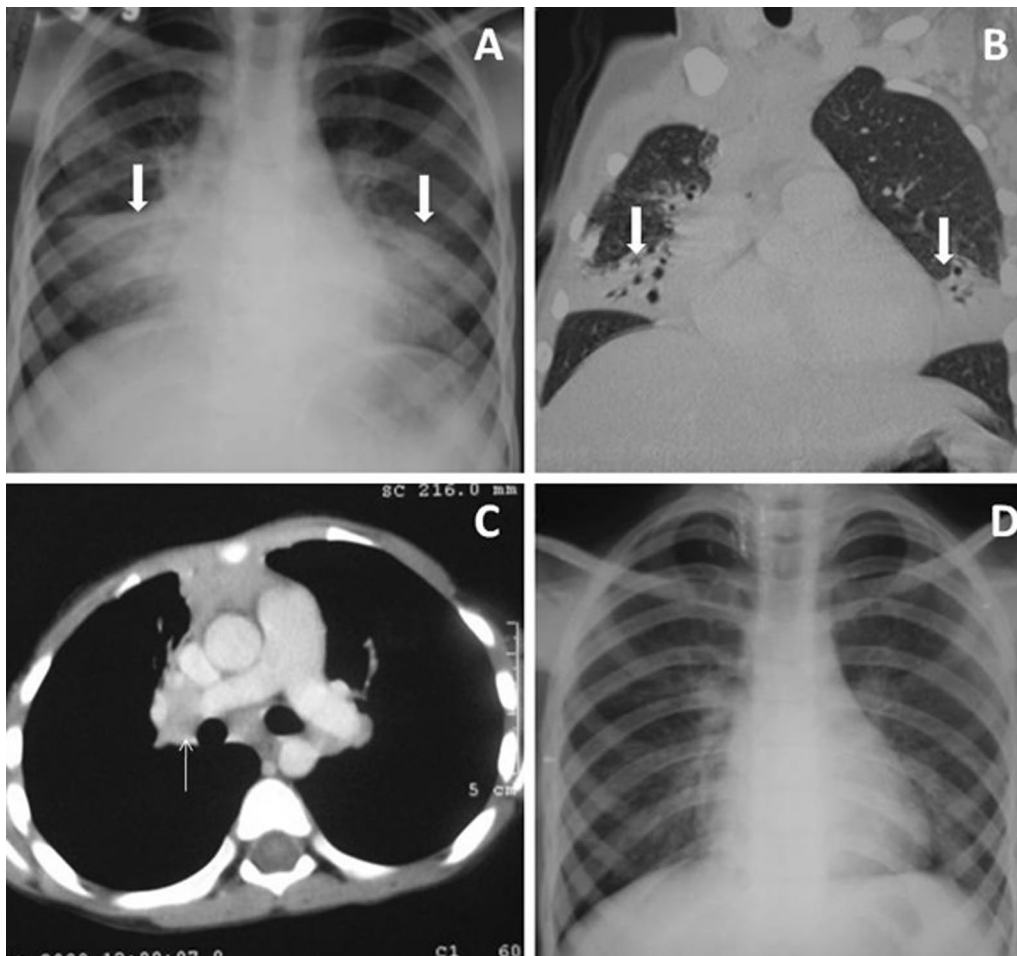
Bacterial Infection. CXR-PA view in a 13-year-old HIV-positive female shows bilateral mid-zone triangular patchy opacities causing silhouetting of adjacent cardiac borders (arrows, A). CT chest shows right middle lobe (RML) and lingular atelecto-brochiectatic changes (arrows in B, lung window), and mediastinal lymphadenopathy (arrow in C, soft issue window). Sputum could not isolate any microorganism. CD4 count was 1001 cells/cu.mm. Patient was given antibacterial antibiotics and improved clinically and radiologically (D) over a period of 4 weeks
